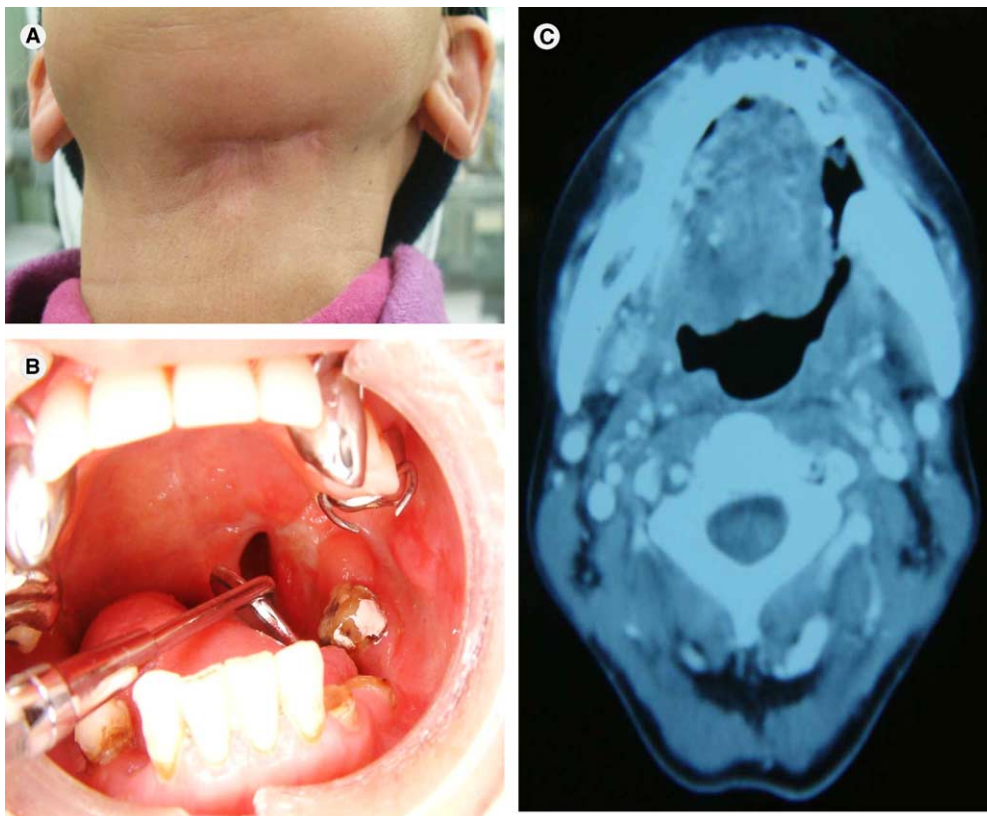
Ten months post-treatment. Extra-oral (A) and intra-oral photograph (B). (C) No tumor observed in computed tomography.
